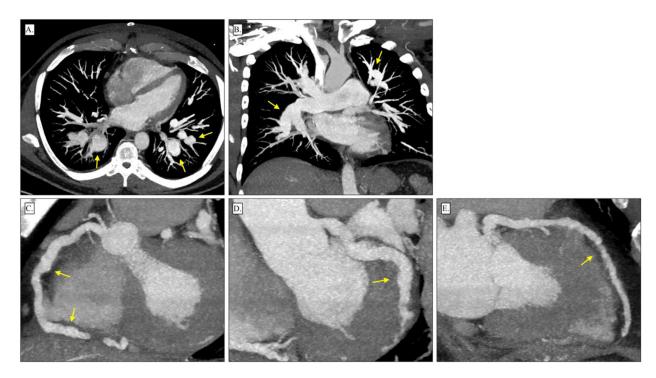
(– A and B) Axial and coronal maximum intensity projection images from a contrast-enhanced chest computed tomography for patient 1 demonstrating multiple fusiform and saccular segmental and subsegmental pulmonary artery aneurysms (arrows). (C-E) 3D reformatted images from a contrast-enhanced prospectively gated cardiac CT images of patient 1 demonstrating the (C) right coronary, (D) left circumflex, and (E) left anterior descending arteries. There is diffuse ectasia of the coronary arteries with multifocal narrowing and dilatation, resulting in an extensive beaded appearance. Segmental regions of mild perivascular soft tissue thickening are also present (arrows).
